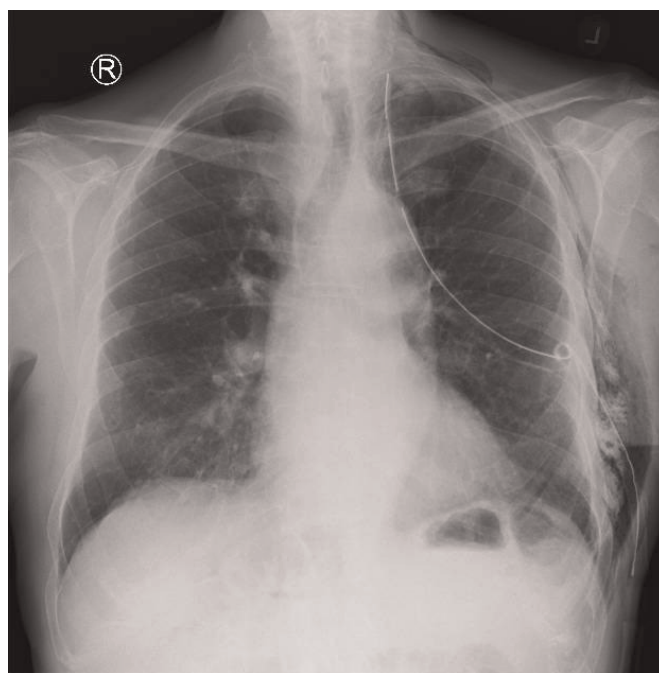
Chest radiograph showing lung expansion (not total) and good drain placement.
